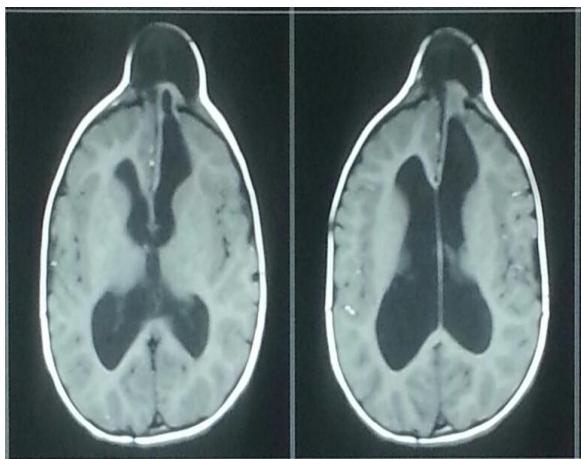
T1 MRI image showing protrusion of the CSF and the brain parenchyma through the bony defect in the frontal bone s/o encephalocele.
